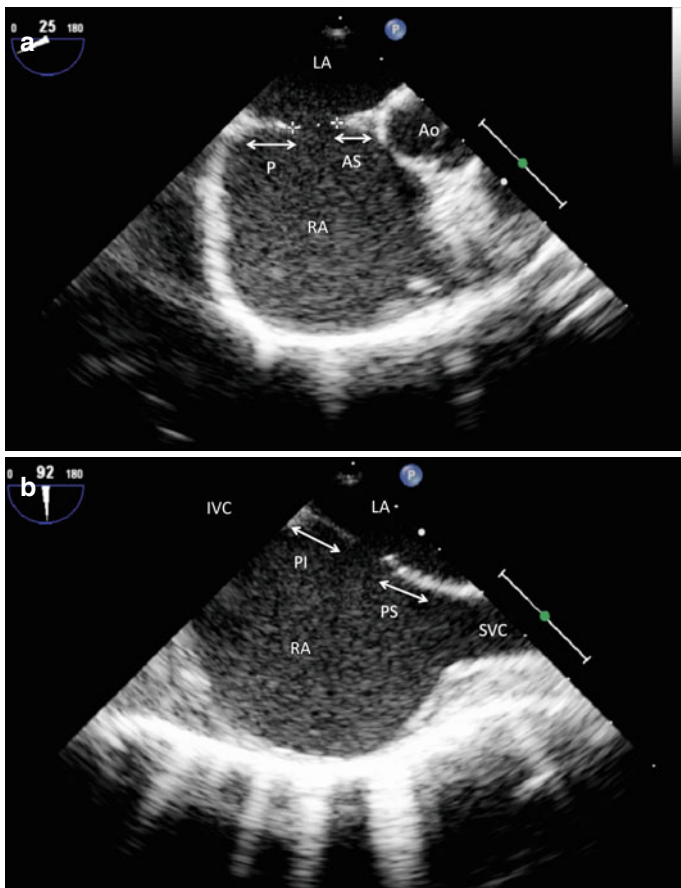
(a) Trans-oesophageal echocardiography, “30°” view. RA right atrium, LA left atrium, Ao aorta, P posterior atrial rim, AS anterior-superior atrial rim. (b) Trans-oesophageal echocardiography, bi-caval view. PI postero-inferior atrial rim, PS postero-superior rim. The arrows delineate the extent of the tissue margin around the defect
